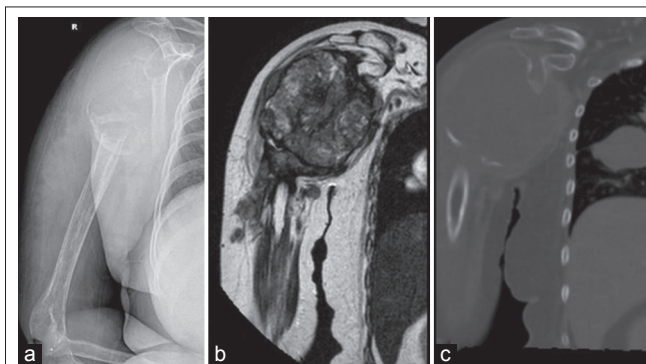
Plain radiograph of right humerus showing an expansile lytic lesion, (a) Magnetic resonance imaging showing a large destructive lesion with cortical breach and soft tissue extension, (b) Computerized tomographic scan of humerus and chest showing aggressiveness of tumor and cannonball metastasis (c).
